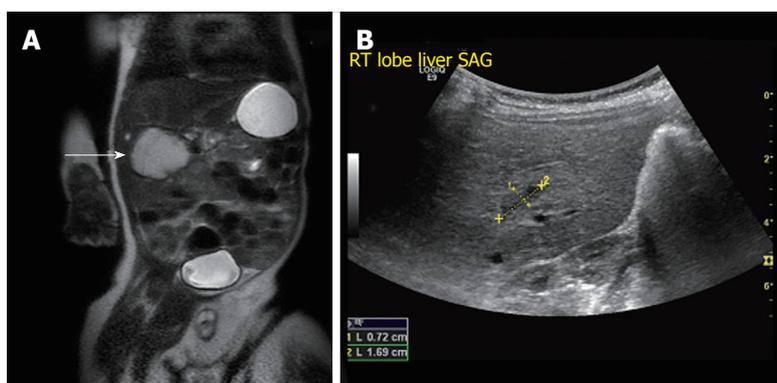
Focal infantile hepatic hemangiomas. A: Coronal T2 weighted MRI image through the abdomen of an 8-wk-old boy revealing a large hyperintense mass arising from the liver (arrow); B: Abdominal USG of the same patient at 17-mo-old shows a minimal residual scar (demarcated by calipers). USG: Ultrasonography; MRI: Magnetic resonance imaging.
